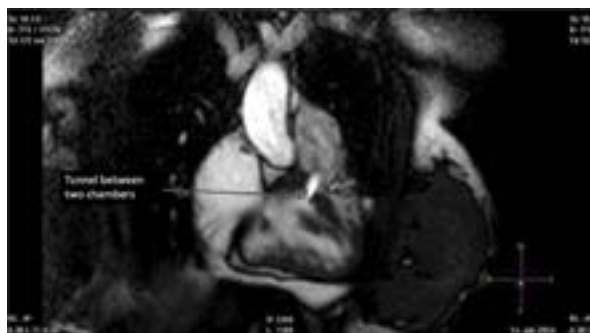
Magnetic resonance imaging of the heart shows anomalous muscle band (arrowheads) dividing the right ventricle
